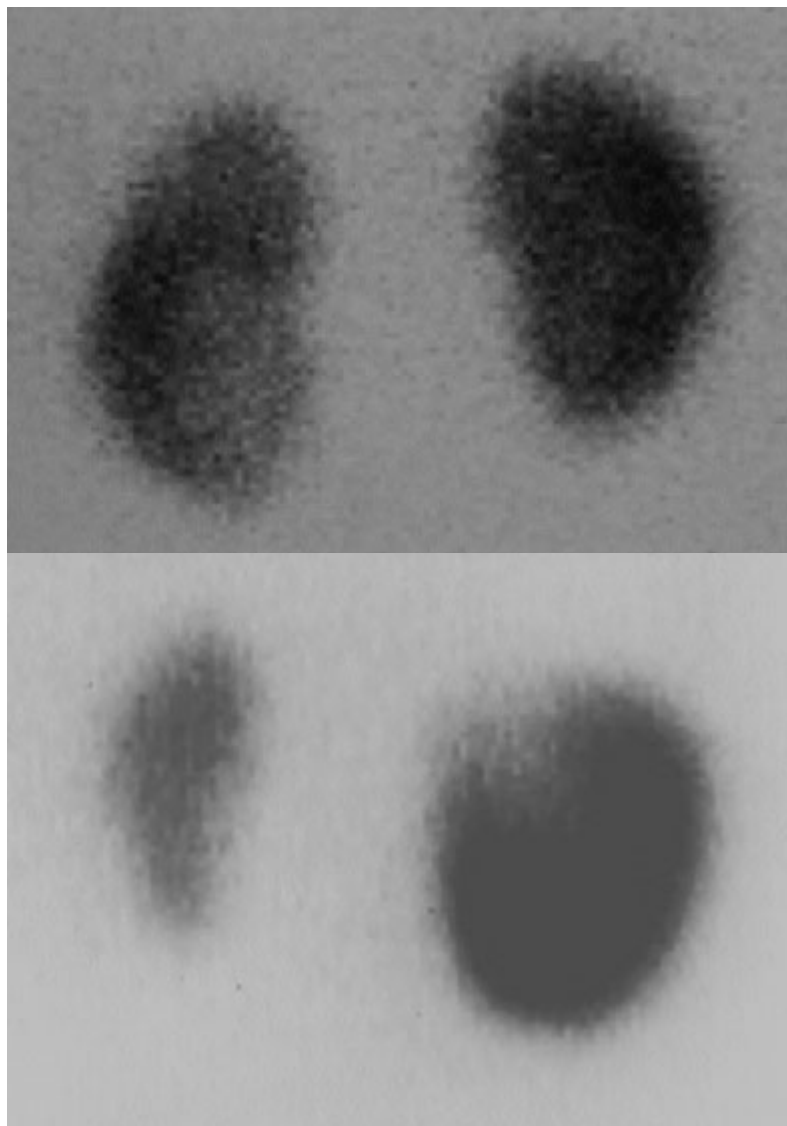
Deux exemples de scintigraphie (Cystographie sus pubienne) au DMSA.
